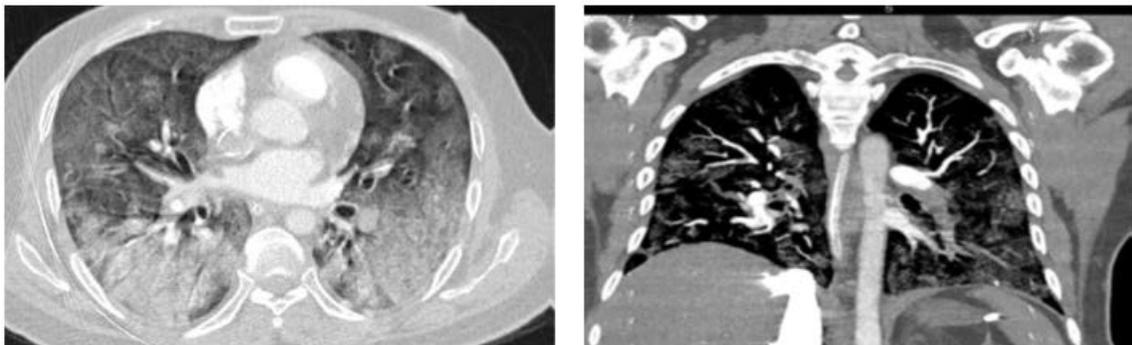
Lung window of case 5 showing features of COVID 19 infection. Coronal MPR CT pulmonary angiography shows thrombus in right descending pulmonary artery and its
